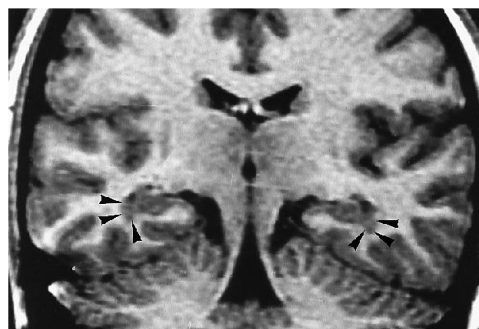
Patient 1: heterotopia. Oblique coronal T1-weighted section at the level of the body of the hippocampal formation. Bilateral small clusters of heterotopic gray matter were present in the white matter of the temporal lobes lining the lateral borders of the temporal horn of the lateral ventricles (arrows). The hippocampal formations and the neocortex of the temporal lobes had normal appearance.
